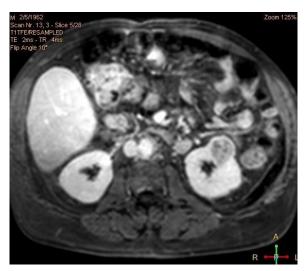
Left kidney tumour. T1 GAD-enhanced MRI displaying a small capsulated lesion without renal sinus invasion.
